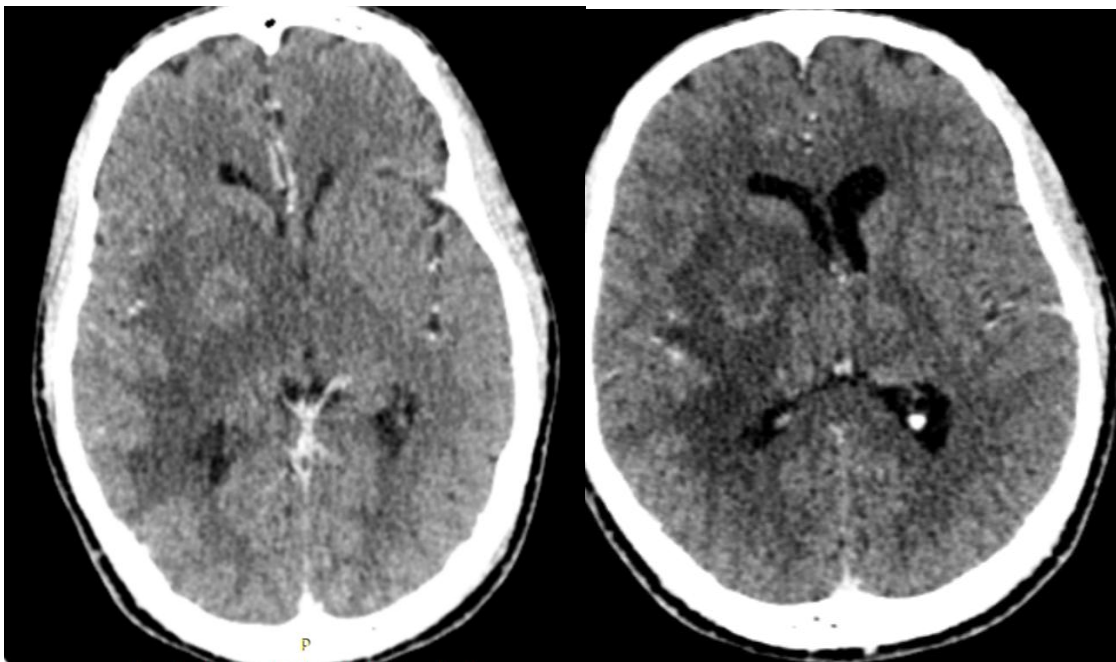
Selected axial contrast enhanced CT brain of a 33 year old male demonstrating a rim enhancing abscess centred in the right basal ganglia. There is marked perilesional oedema and mass effect. The patient presented with left hemiplegia and convulsions. CT scan was acquired 72 hours after symptom onset.
